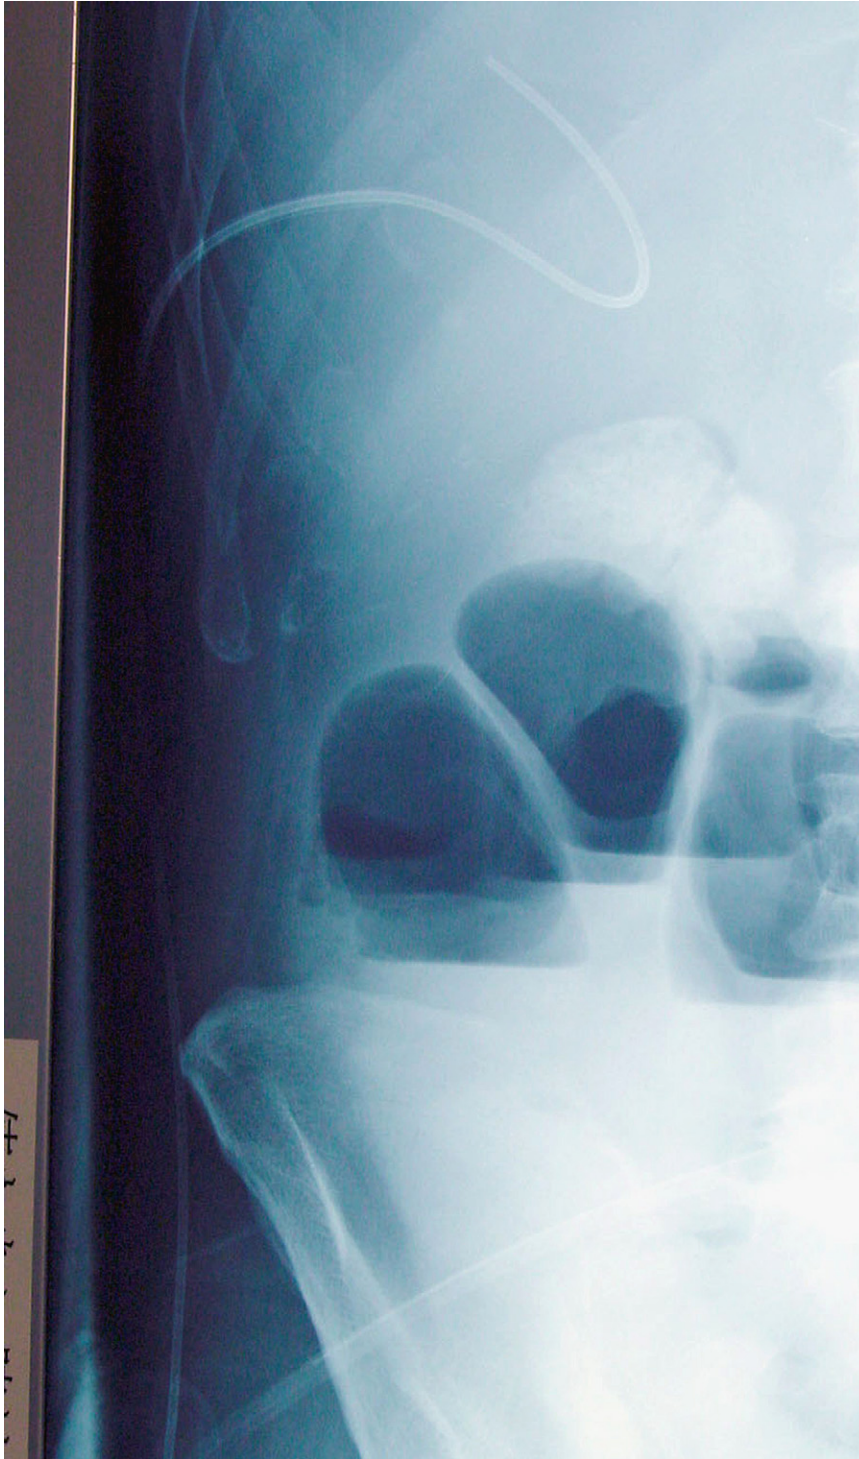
A abdominal X-ray film revealed that the PTCA catheter was taped to the abdominal wall without forming a loop.
